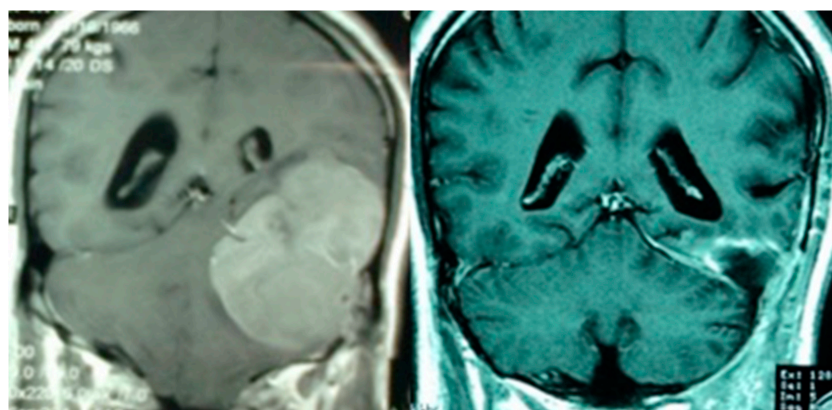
Contrast MRI of brain coronal sections; left side shows huge preoperative tentorial meningioma and right side shows postoperative complete excision of meningioma. Source: Figure by authors.
